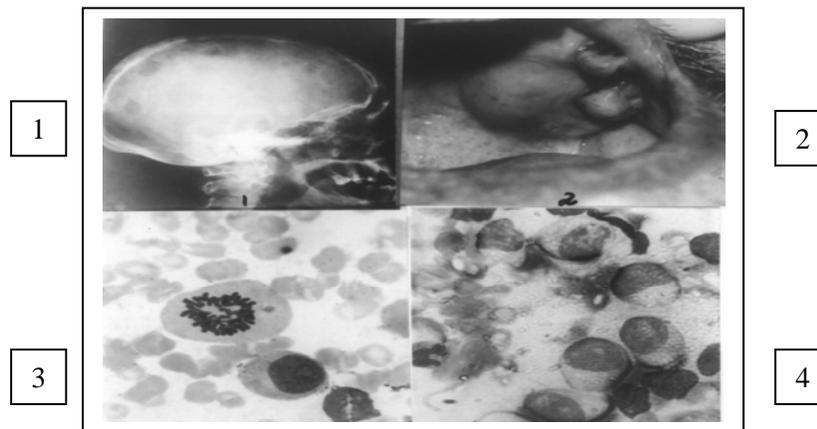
A patient with MM, (1)Skull X-ray showing multiple osteolytic lesions (2) Palatal mass (3) and (4) FNA smears showing sheets of myeloma cells with a mitotic figure (x1000).
